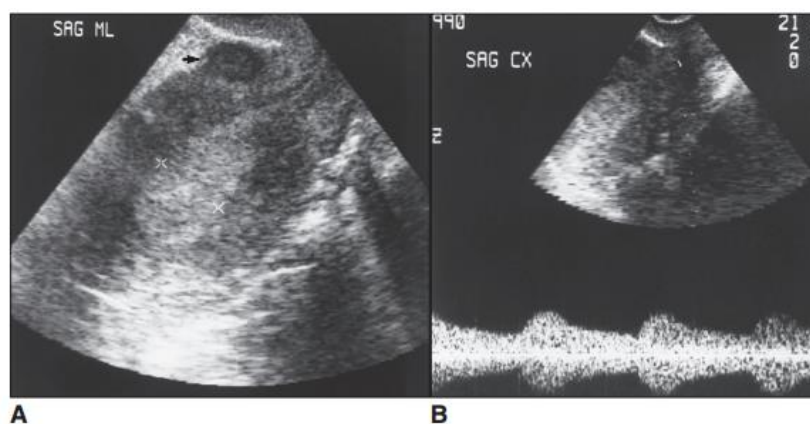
endometrial carcinoma in a 52-years-old women. A, sagittal view of the uterus. B, Doppler examination of the uterine artery.
